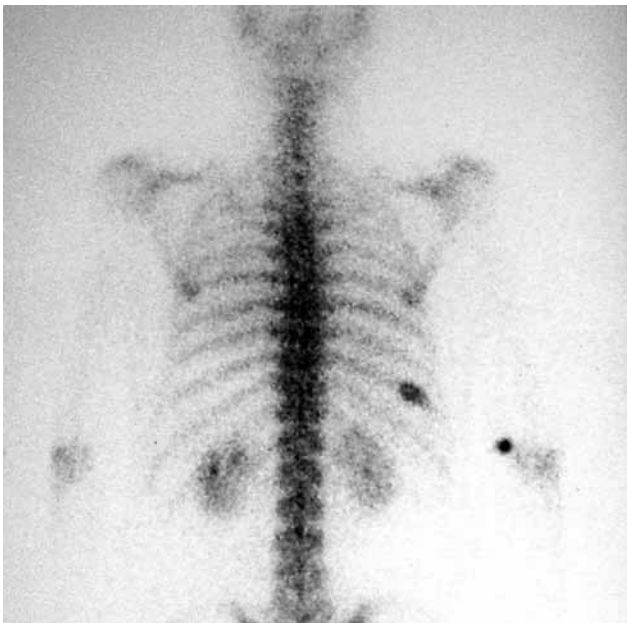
Technetium-99m methylene diphosphonate scintigraphy showing a suspicious malignant lesion.
